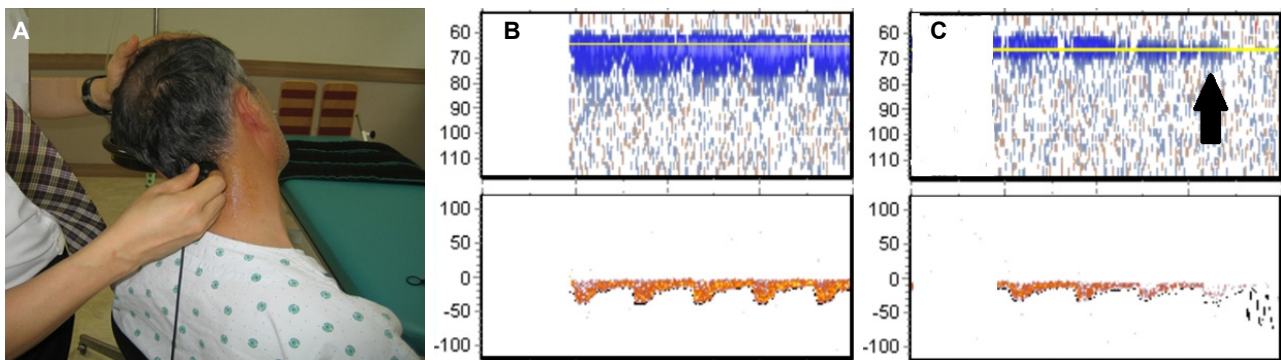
Midbasilar artery flow rapidly disappeared while the patient rotated and sustained his neck to the left. (A) After placing transcranial doppler (TCD) probe at midbasilar artery, the patient is asked to rotate his neck to left side (45 degrees extension and 70 degrees rotation in detail). (B) Normal TCD waves of midbasilar artery. (C) Rapid disappearance of TCD waves while the patient rotates and sustained his neck (black arrow)
